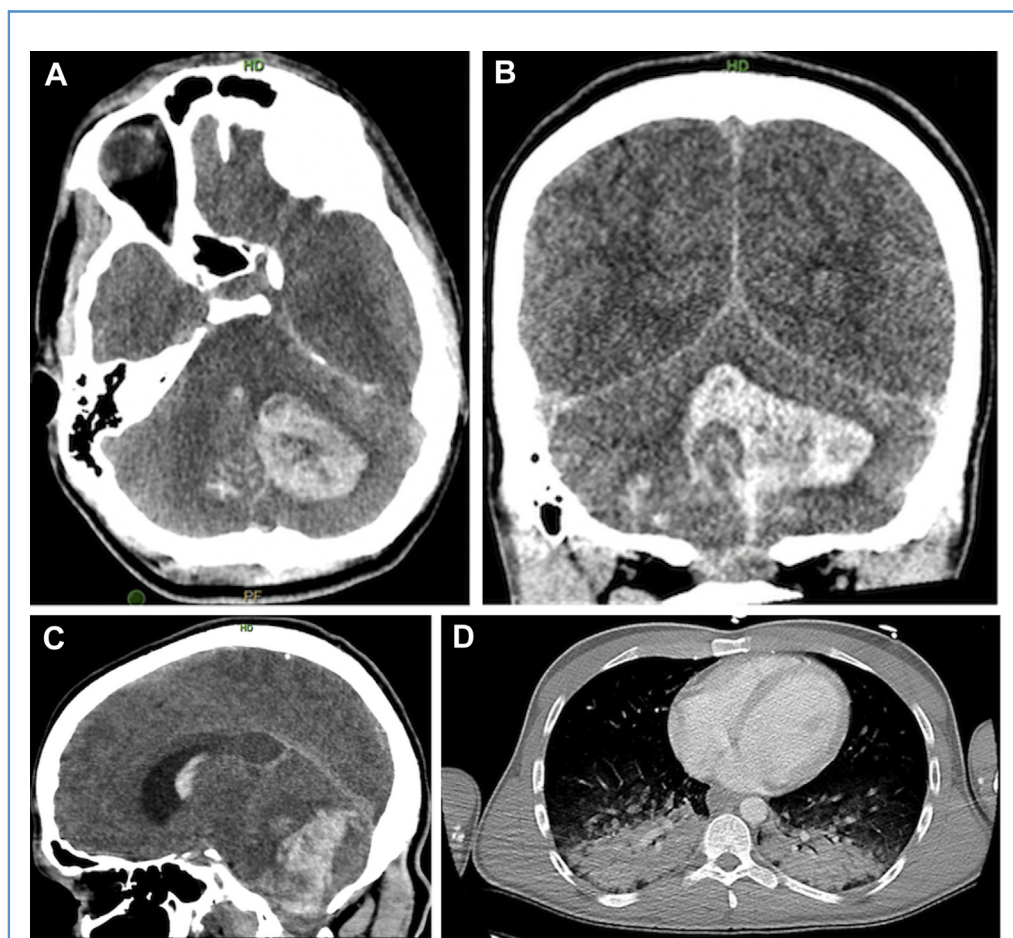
(A–C) Axial, coronal, and sagittal noncontrasted computed tomography (CT) images of the head of a previously healthy 24-year-old male patient who presented after a syncopal episode at home followed by unresponsiveness. On arrival, he had no extremity movements, pupils were fixed, dilated, and nonreactive, and he had no brainstem reflexes. CT of the head (pictured here) demonstrated a large posterior fossa hemorrhage centered in the left
